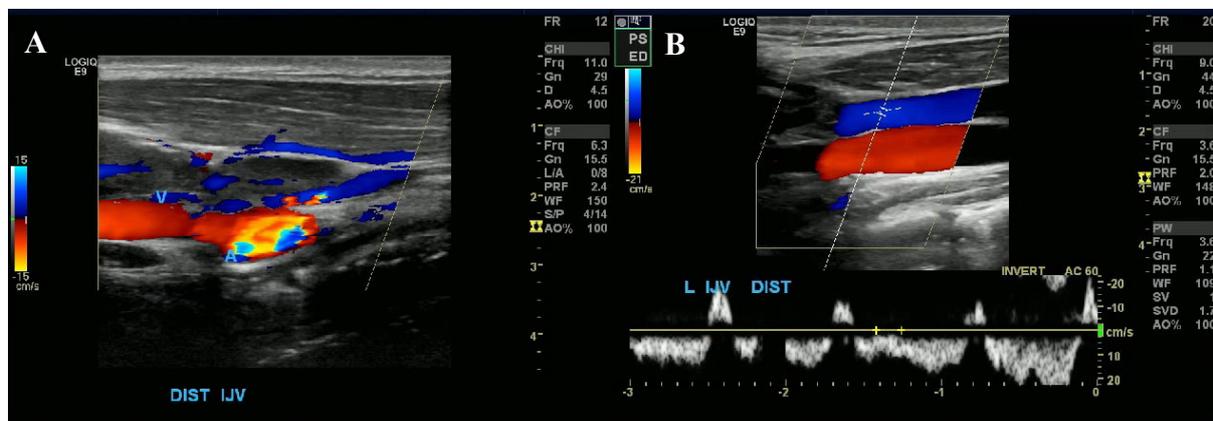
Ultrasound of the neck: (A), intraluminal echogenic filling defect within the distal left jugular vein which was non-compressible, consistent with a non-occlusive thrombus. (B), repeat ultrasound after the initiation of therapy demonstrating very minimal residual thrombosis of the distal IJV.
